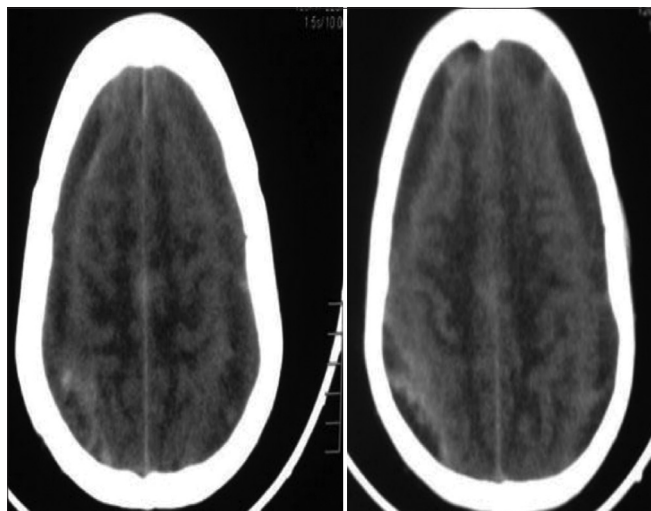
Preoperative non-contrast computed tomography head of case 1 showing bilateral subdural haeamtoma
